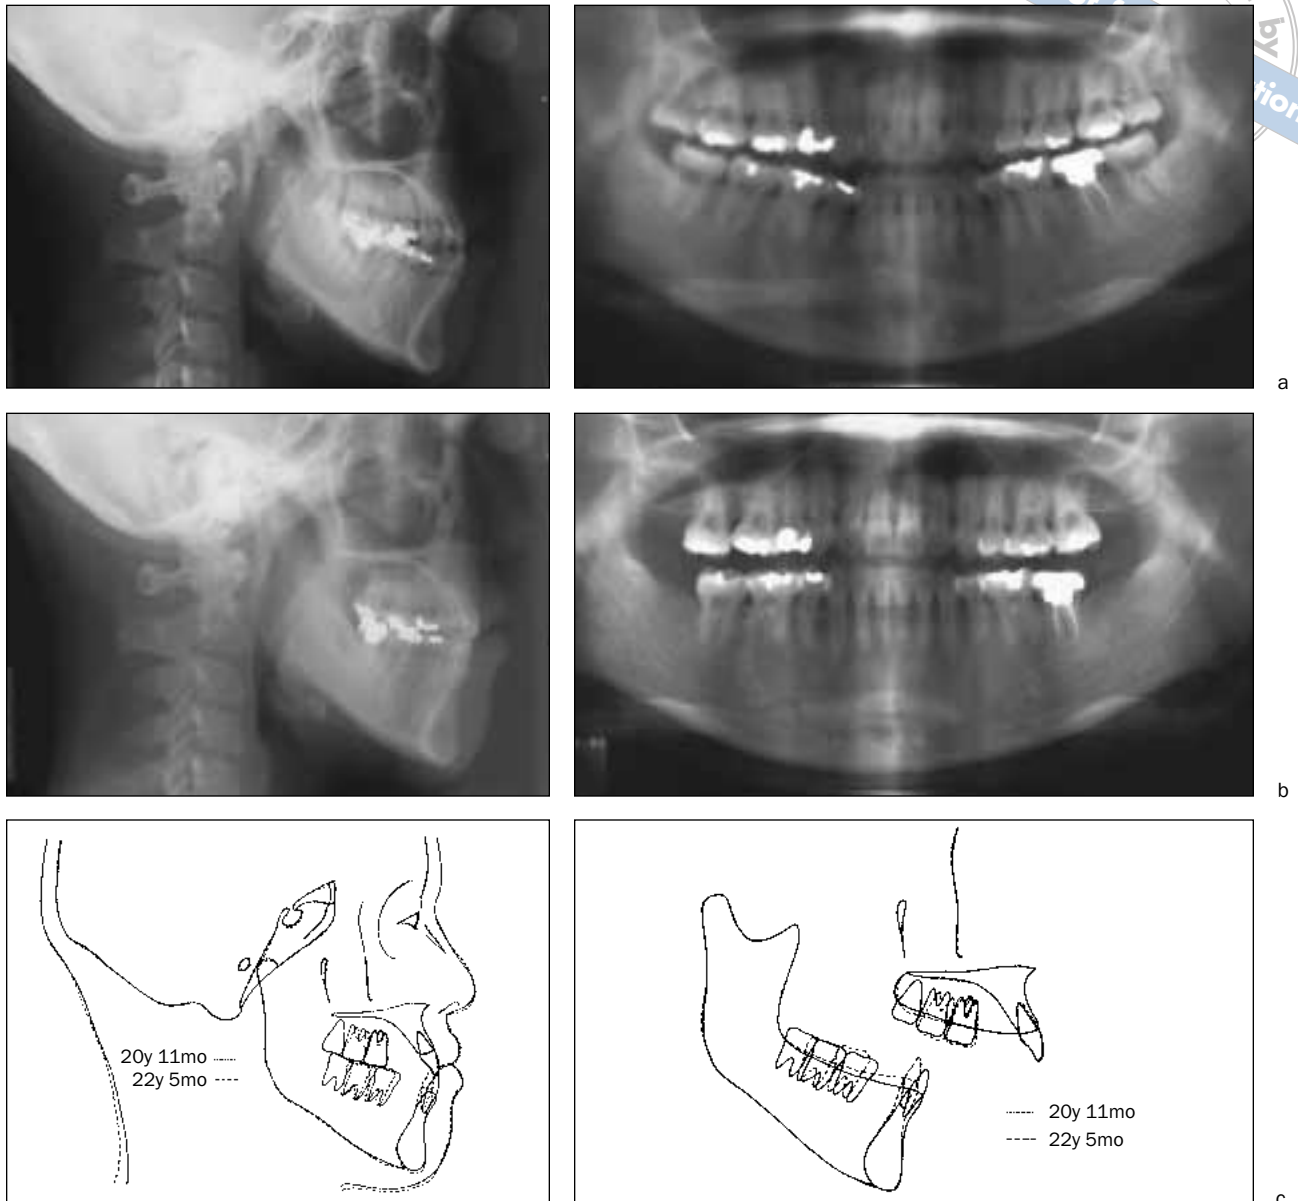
Case 3. (a) Pretreatment cephalogram and panoramic radiograph. The ODI was 60 degrees and the APDI was 91 degrees. This indicated a Class III skeletal pattern with an open bite tendency. (b) Posttreatment cephalogram and panoramic radiograph show an excellent dental relationship. (c) Posttreatment cephalometric superimposition reveals that there were no changes in the skeletal pattern, but the mandibular dentition was distalized and significantly uprighted.
